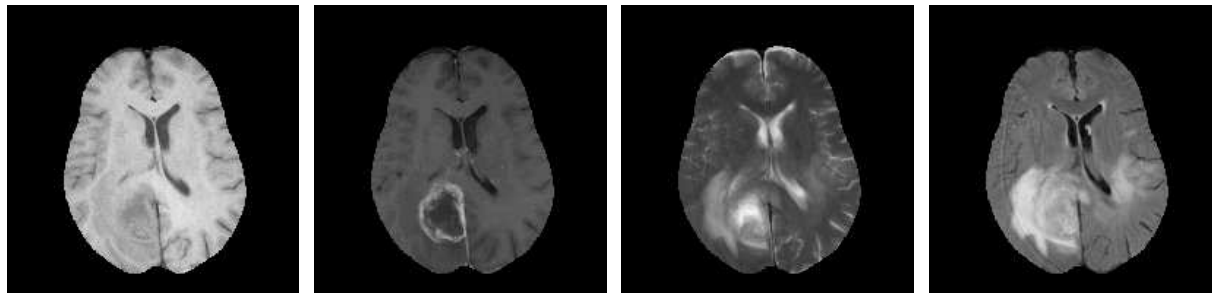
Example of an axial slice of different MRI sequences showing a GBM tumour. From left to right: T_1 , T_{1c} , T_2 and FLAIR image.
